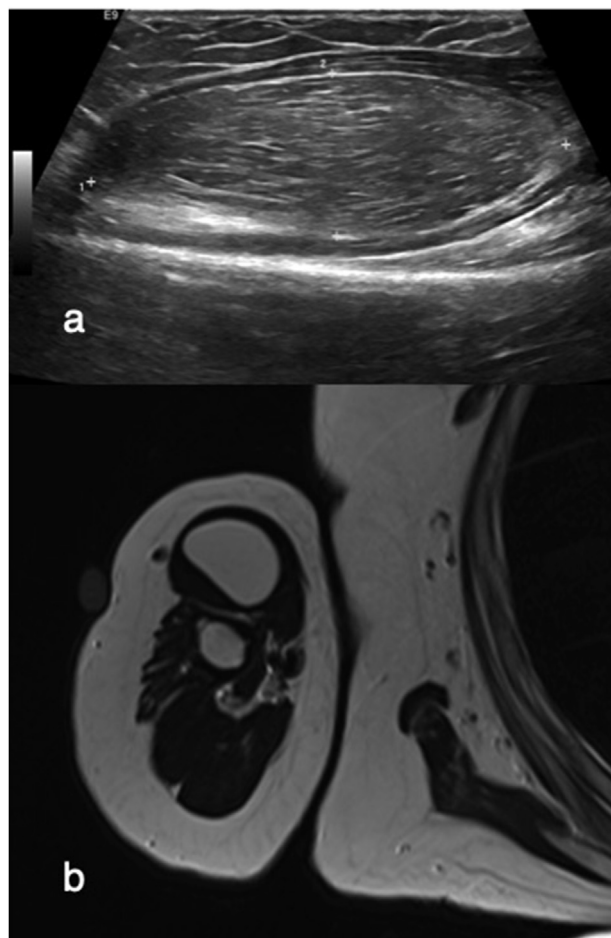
Intramuscular lipoma. A longitudinal ultrasound view through the right upper arm (a) reveals an encapsulated intramuscular fat-containing lesion within the biceps brachii suggestive of an intramuscular lipoma. An axial T1W image (b) confirms a well-defined fat-containing intramuscular lesion diagnostic of a lipoma.
